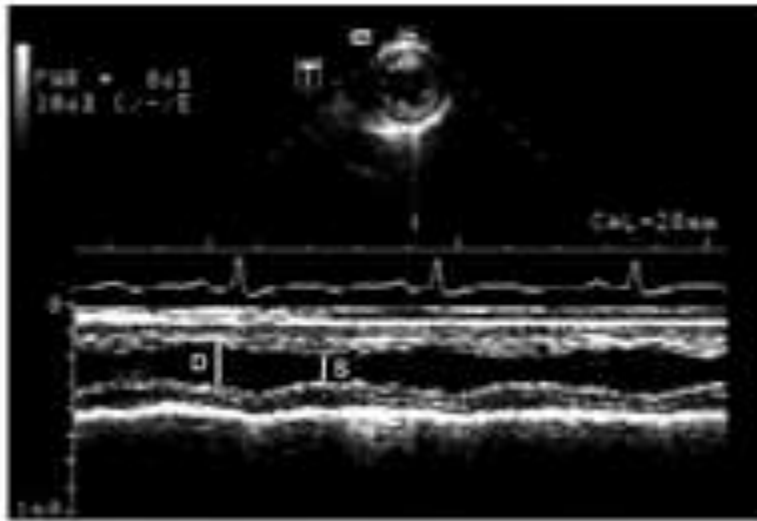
Fractional shortening of the left ventricle is derived from an M-mode view of a transgastric mid short axis echocardiogram. The internal diameters of the LV are measured during diastole (D) and systole (S) (Fox et al., 2003).
